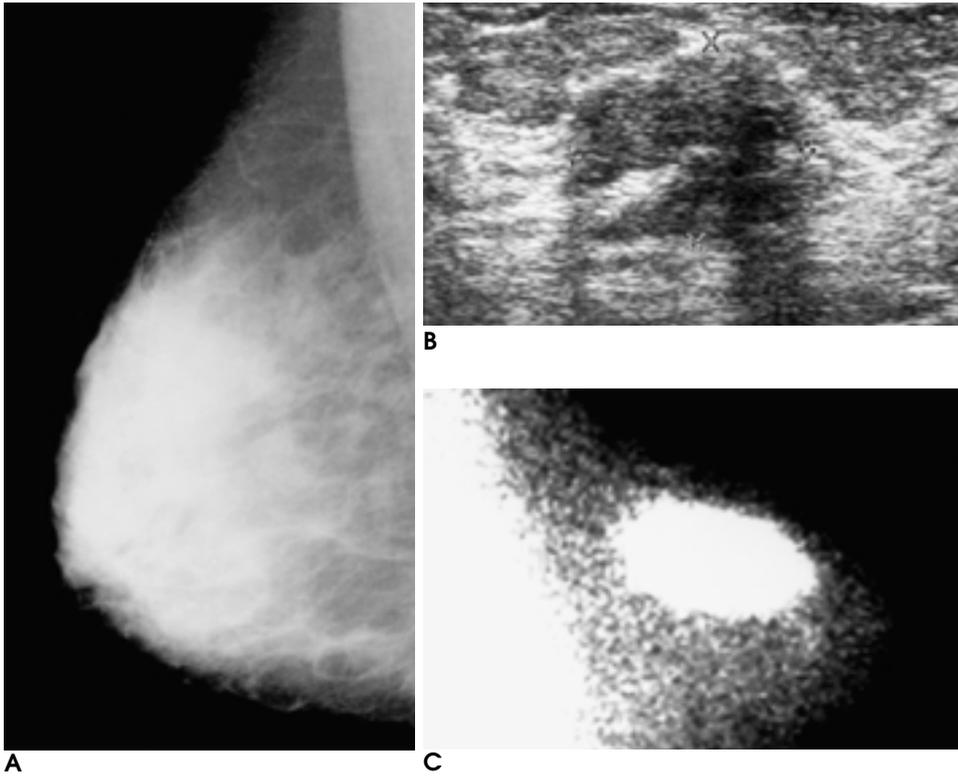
Invasive ductal carcinoma in 41-year-old woman has difficulty in interpretation of mammogram due to dense parenchyma, but malignant mass is diagnosed on ultrasonography and ^{99m}Tc-MIBI scintimammography.
